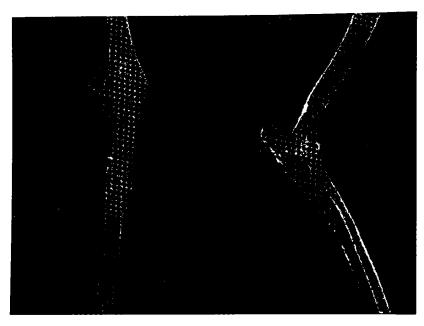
The anteroposterior and mediolateral radiographic views of case 4 when plate and screws removed on 6th months. Şekil 9. Olgu 4'ün postoperatif 6. ayda plak ve vidalarının uzaklaştırılmasından sonraki anteroposterior ve mediolateral radyografik görünümleri.
